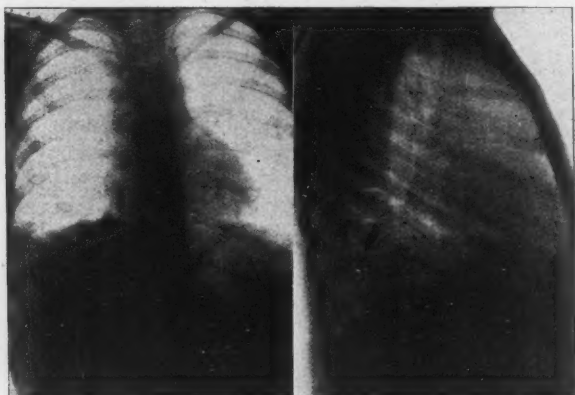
Roentgenogram showing a metallic foreign body deep in the lung of a boy aged 8 years. Considering the depth of the foreign body, in the liver shadow below the level of the top of the dome of the diaphragm, and the superjacent tissue barrier that had to be circumvented, the successful peroral bronchoscopic removal without anesthesia indicates that there are no fixed limitations to the peroral bronchoscopic removal of foreign bodies from the lung.
